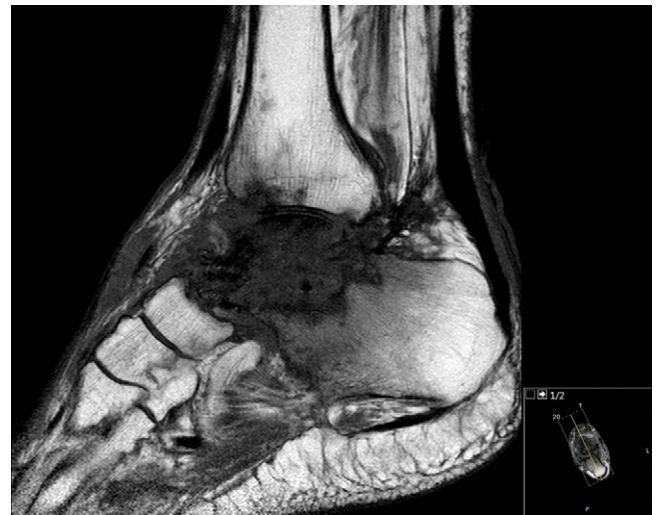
MRI of the right ankle: the talus appears as a hypo-intense signal suggesting an avascular talus.
